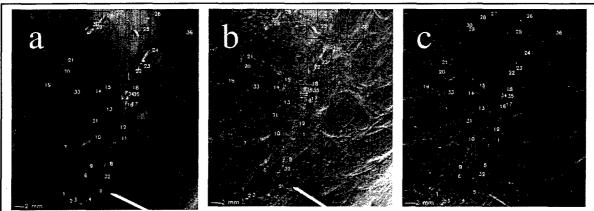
Peak images of the three tissue samples: a) synchrotron-based radiograph, b) peak image, c) refraction image. The numbered, red boxes indicate the calcifications, which were identified and analyzed.
